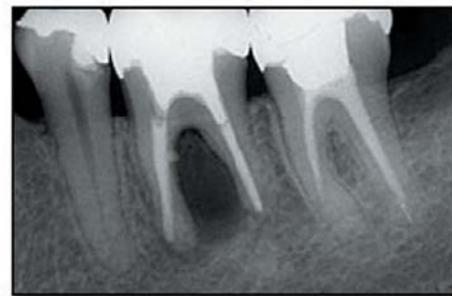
Periapical radiograph view demonstrating the furcation bone defect and the root perforation.
